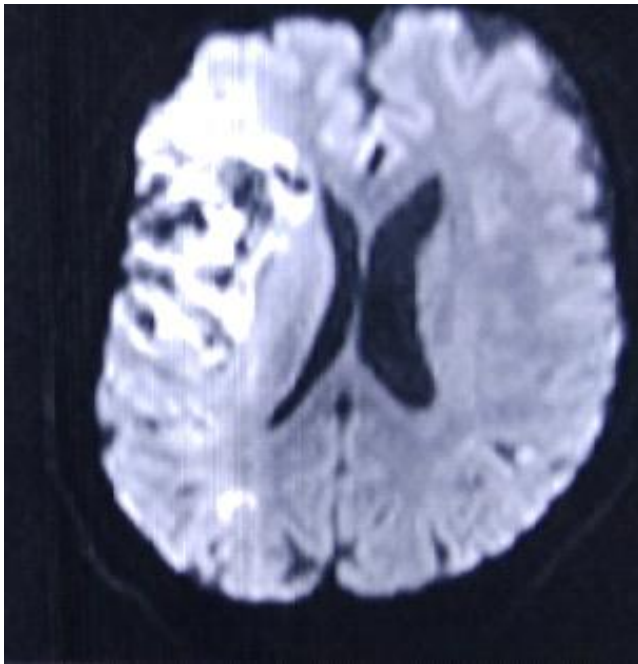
MRI -DWI ADC showing Rt MCA malignant infarct; 6 hrs post ictus
